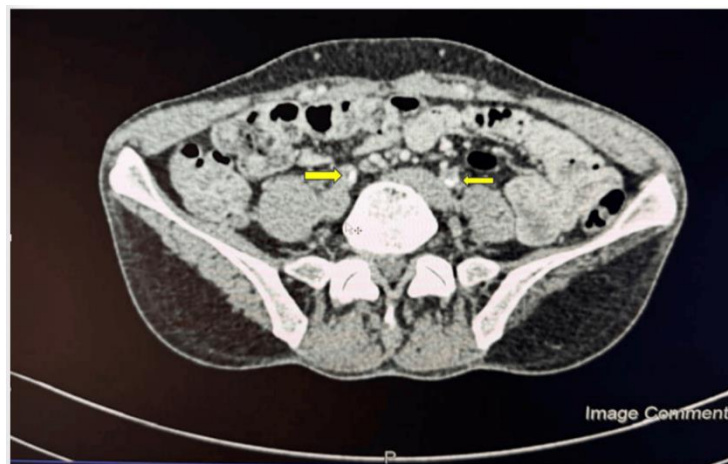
Axial computed tomography angiography image demonstrating thrombotic occlusion of the primitive iliac arteries (arrows indicate areas of thrombosis)
